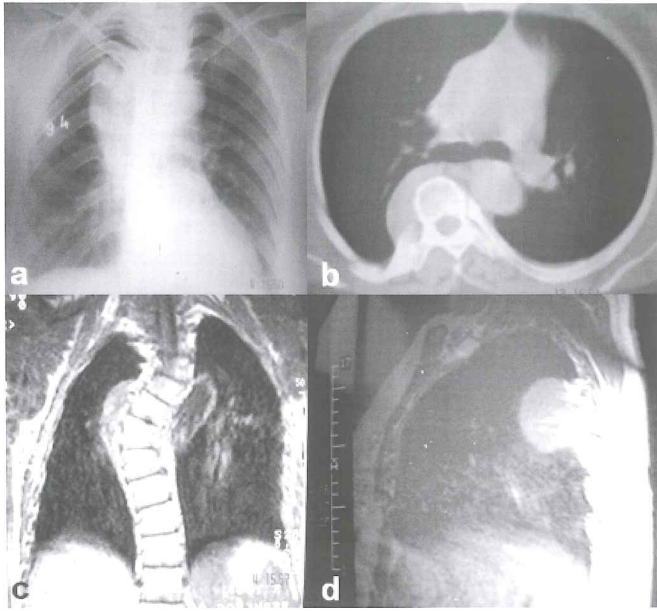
(a) P-A Chest X-ray, (b) axial computed tomography section, (c) coronal MRI section and (d) sagittal MRI section demonstrated a mass lesion at right upper mediastinum
